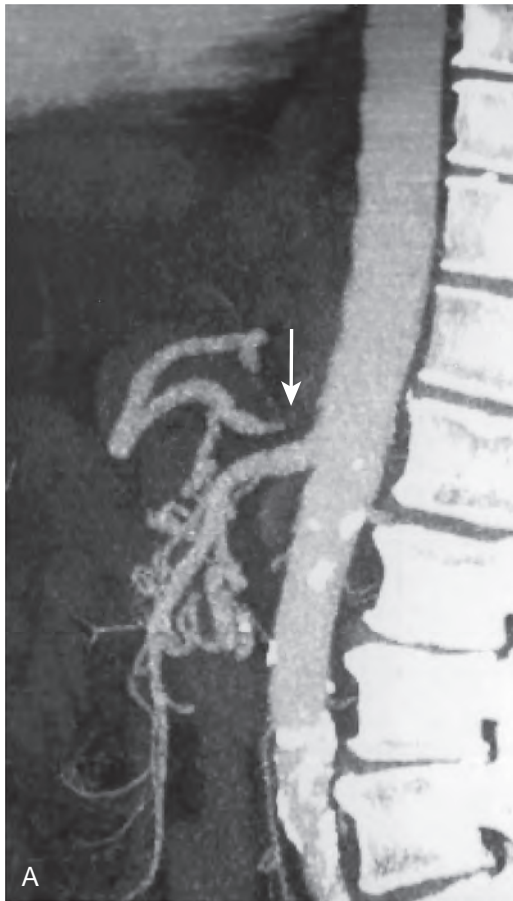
CT angiogram in a patient with celiac artery stenosis. A. Sagittal volume-rendered CT image shows marked narrowing (arrow) at the origin of the celiac artery. B. Coronal MIP image shows the pancreaticoduodenal collateral pathways (arrow) that have developed between the SMA and celiac axis.
